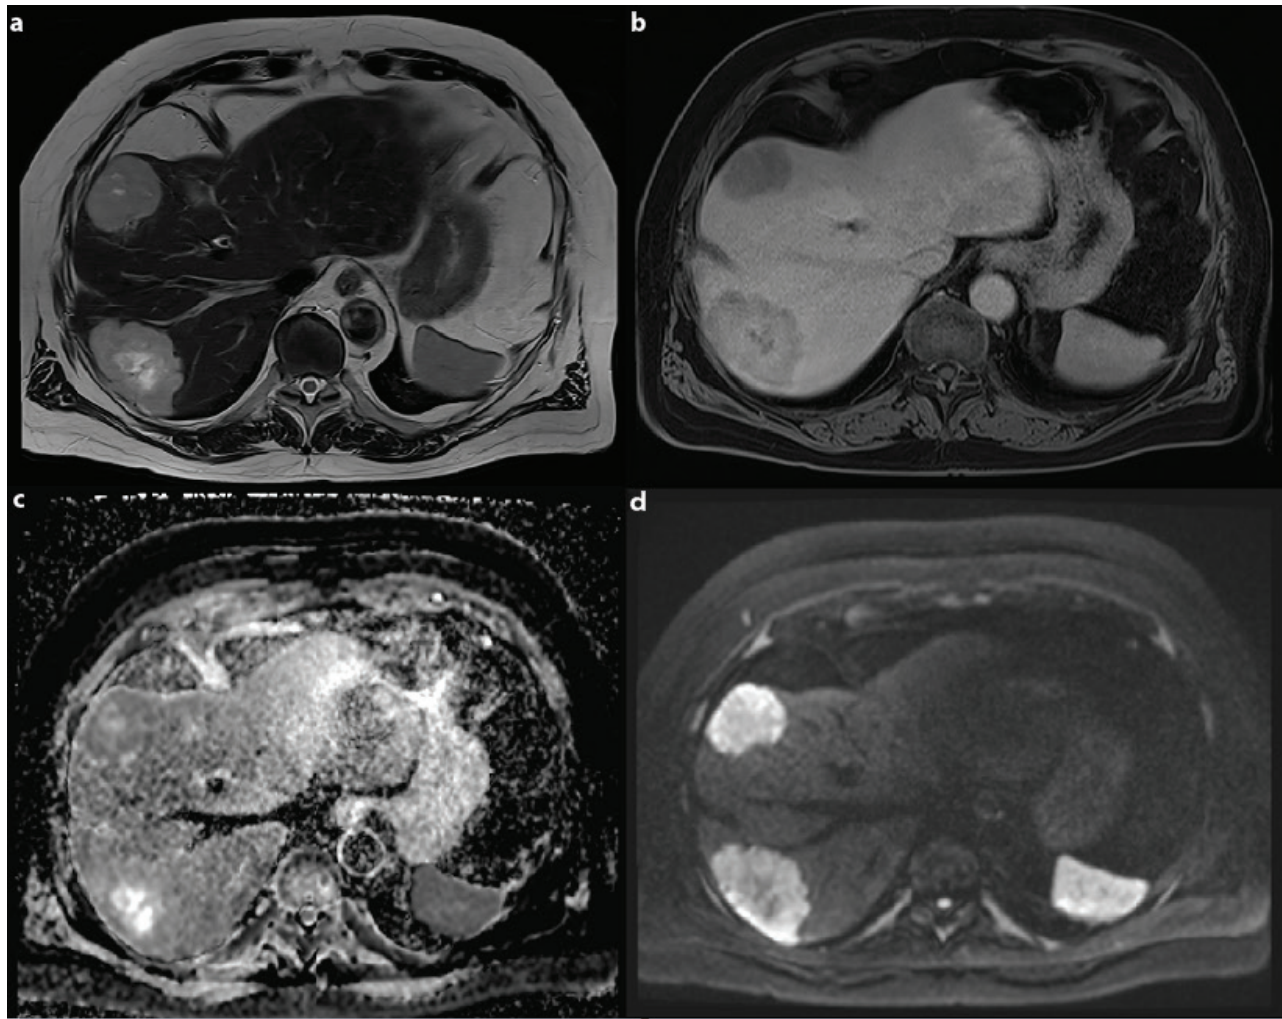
Image panel shows two liver masses in liver segments VII and VIII, proven to be renal oncocytoma metastasis in surgery. T2-weighted image (a) shows well-circumscribed masses with intermediate T2 signal intensity. T2 hyperintensity can be seen in the central parts corresponding to a stellate scar, which can be seen in oncocytomas. Masses demonstrate heterogenous enhancement with gadoxetate disodium (Primovist) in venous phase and delayed phase (b) with no visual enhancement in the scar. Diffusion restriction can be seen in the tumours except in the central scar areas in diffusion-weighted imaging (c, d).
